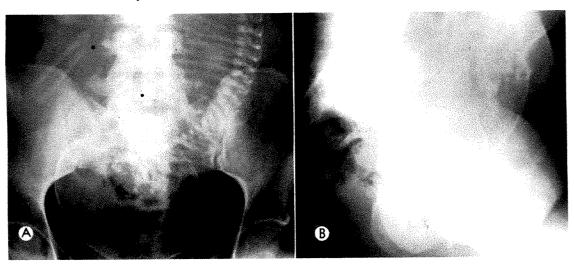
Case IV. (A) Anteroposterior roentgenogram of the abdomen. Numerous small radiolucencies are seen immediately above the symphysis. (B) In the lateral view, areas of emphysema are again observed in the central one-third of the midpelvic plane.
